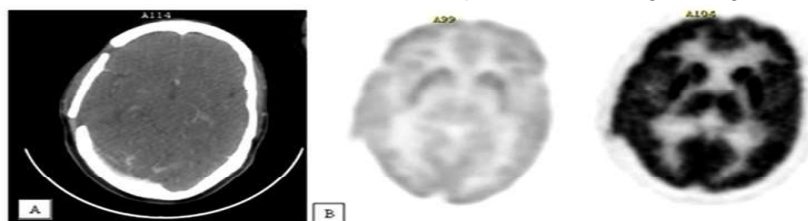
(A) CECT brain showing no residual lesion (B) PET CT brain showing no residual lesion in brain.
